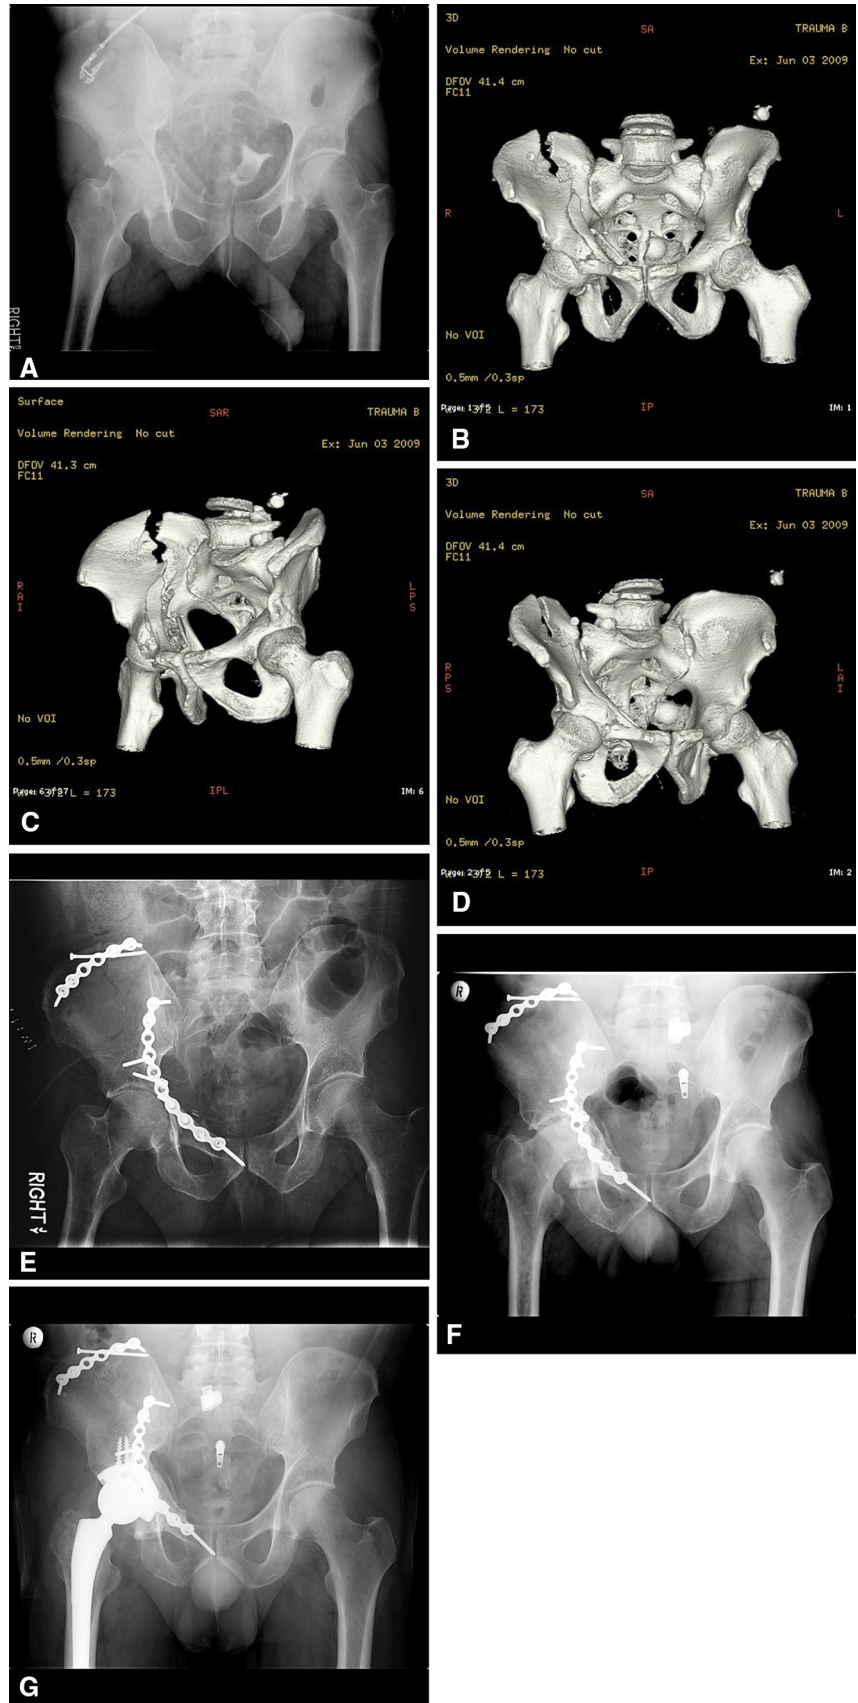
A right-sided comminuted anterior column acetabular fracture is shown in A through D, whereas the immediate postoperative AP radiograph is shown in E. Significant post-traumatic degenerative changes are seen by 9 months postoperatively (F), and this patient ultimately underwent THA with successful improvement of pain and outcome (G).
